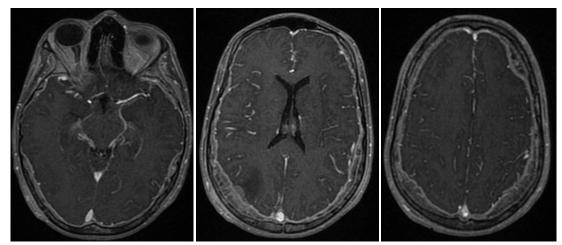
Image showing sections of axial brain MRI, T1 sequence with gadolinium injection, showing contrast uptake
